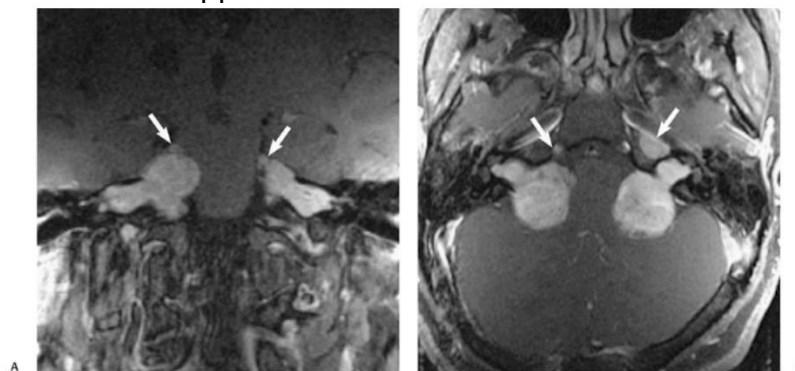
Neurofibromatosis type II. (A) Coronal and (B) axial gadolinium enhanced T1-weighted magnetic resonance images show bilateral lobulated, enhancing cerebellopontine angle–internal auditory canal (IAC) vestibular schwannomas extending to the fundus of the IAC bilaterally, and compressing the pons. Note also the presence of bilateral enhancing masses involving the fifth cranial nerves and Meckel's cave (arrows) consistent with schwannomas.
